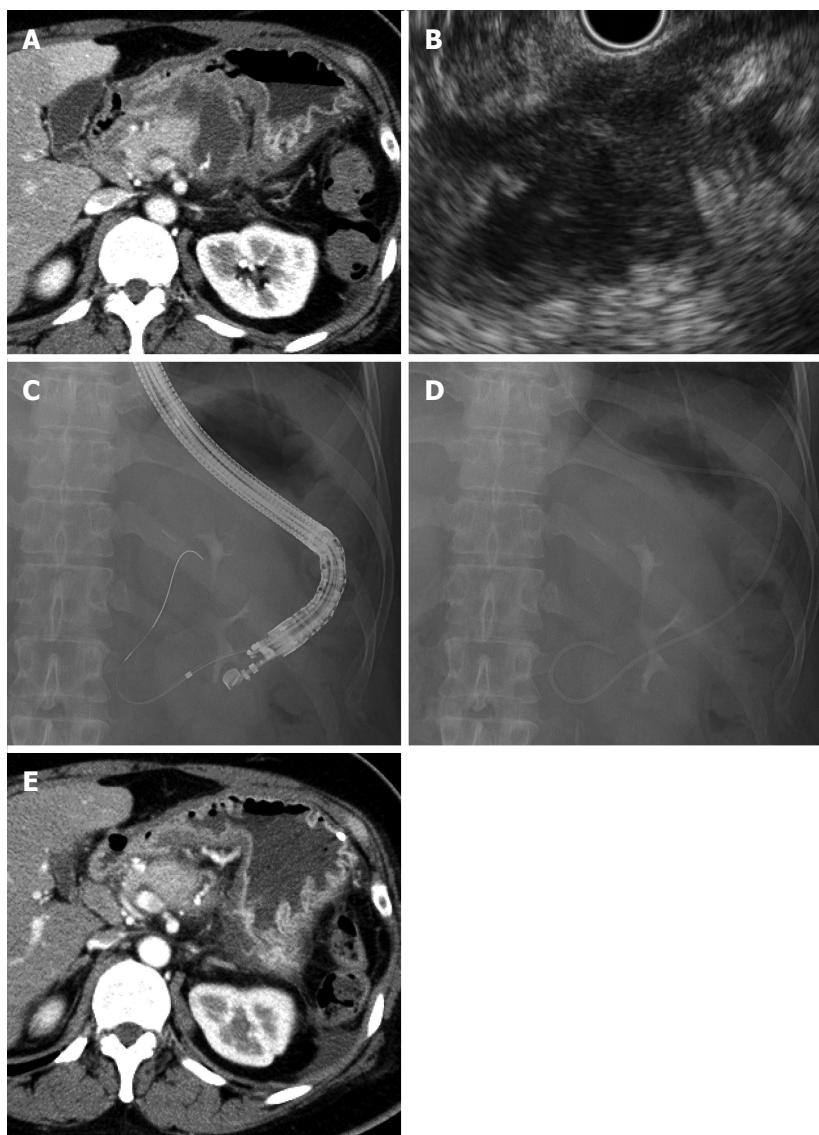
Case 2. A: Computed tomography (CT) reveals irregular fluid collection around the resection stump of the pancreas at the dorsal side of the stomach; B: Endoscopic ultrasound (EUS) reveals an irregular and cloudy fluid collection close to the gastric wall; C and D: Fluoroscopy image showing the dilation catheter inserted over the guidewire and placement of a 6-Fr nasal biliary catheter; E: Eleven days after EUS-guided drainage, CT reveals that the fluid collection decreased.
